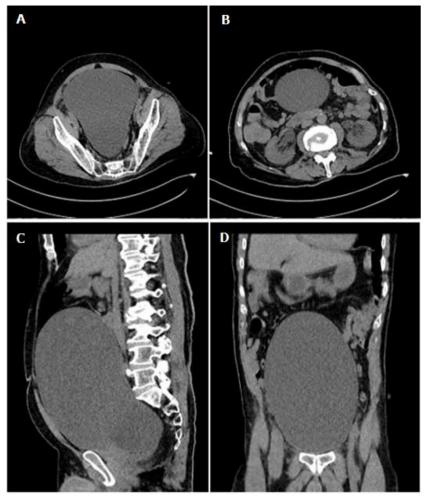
abdominal and pelvic CT showing a bladder with a balloon-like appearance, occupying the entire pelvis and reaching up to the level of the kidneys with bilateral hydronephrosis; A and B: axial sections; C: sagittal section; D: coronal section
